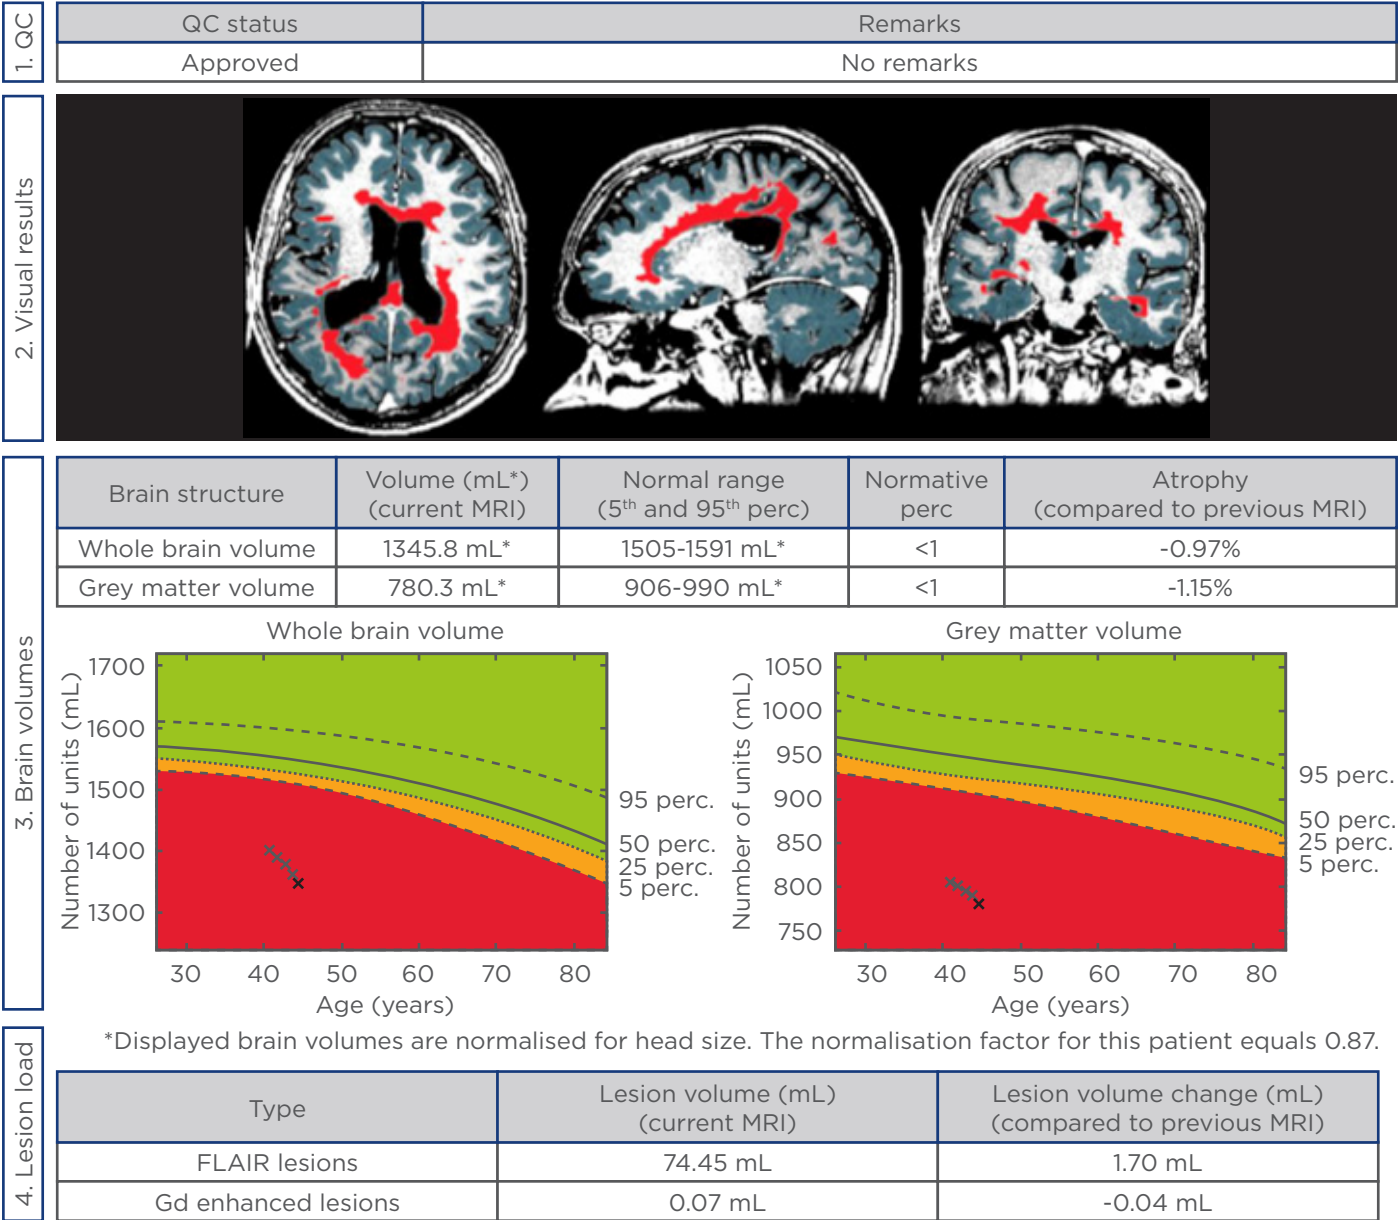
Case study showing reductions in whole brain and grey matter volume in a young patient. Visual representation of T2 lesion load is shown as red areas (visual results, upper section of figure). Volume reduction over time (age of patient) in whole brain and grey matter is indicated by crosses (brain volumes, lower section of figure). QC: quality control; MRI: magnetic resonance imaging; Gd: gadollinium; perc: percentile; FLAIR: fluid attenuated inversion recovery.
